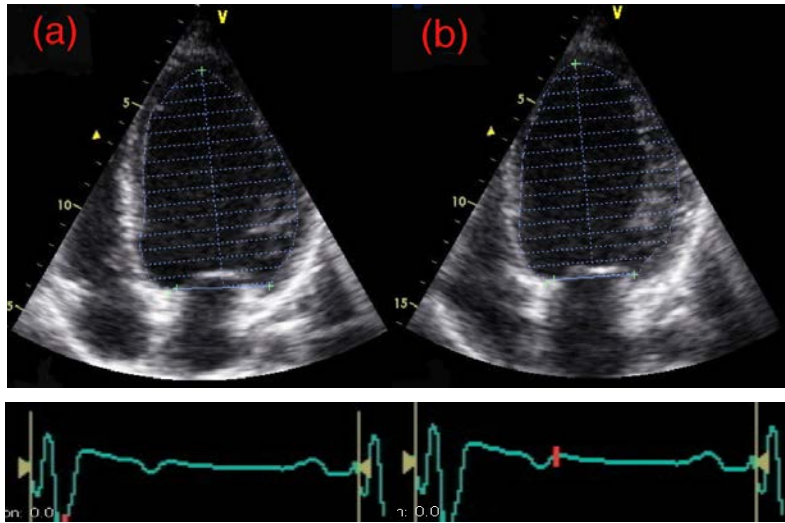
Calculating left ventricular ejection fraction using Simpson's Biplane Method of Discs. The endocardial border of the left ventricle was traced as shown in (a) end diastole and (b) end systole in the apical four-chamber view. The same process was repeated in the apical two chamber view and the LVEF calculated.
